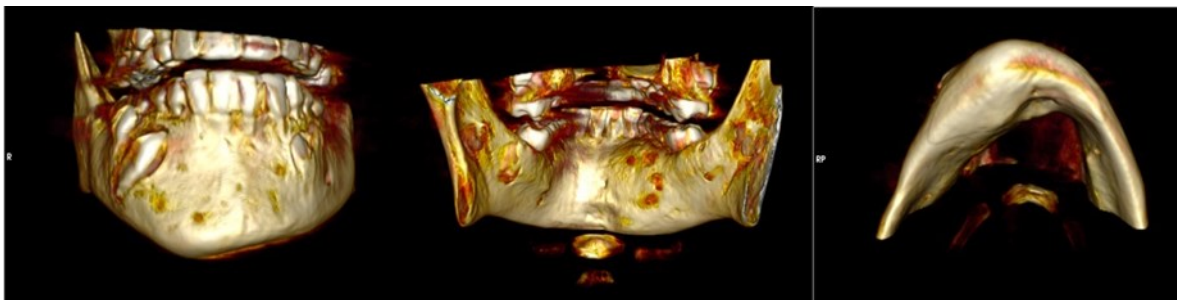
CBCT 3D reconstruction.
